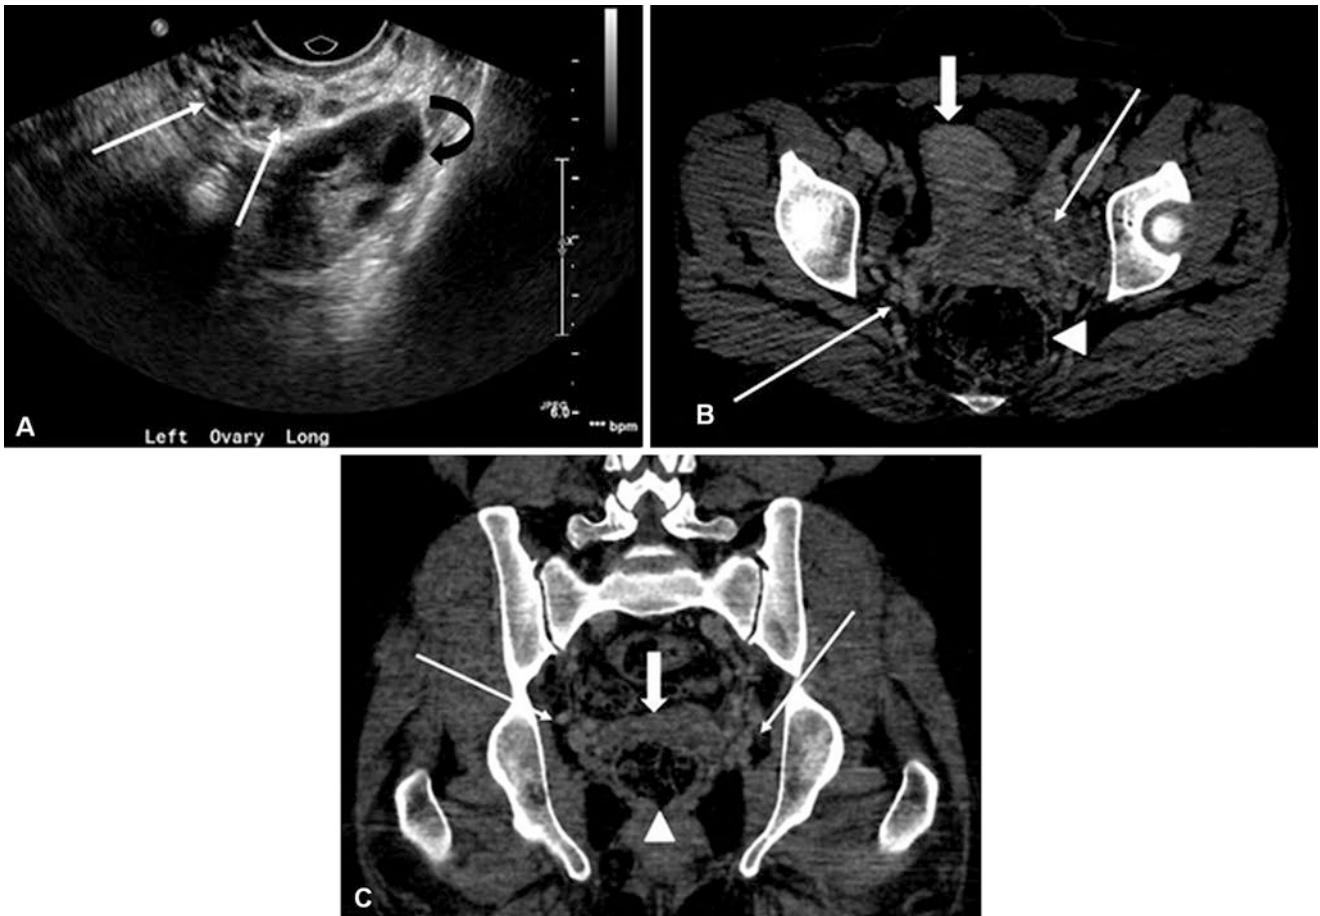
33-year-old female with vulvar varicosities and pelvic heaviness following pregnancy. (a) Transvaginal ultrasound demonstrates multiple tubular structures (thin arrows) consistent with ovarian varices. The ovary demonstrates multiple simple cysts
